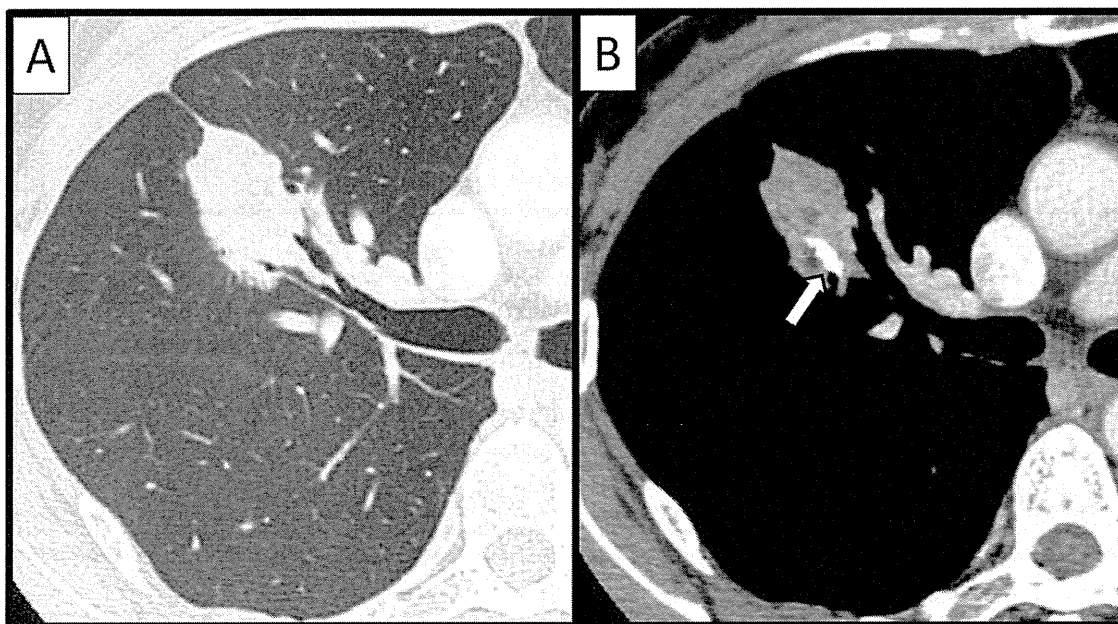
Chest CT of the second tumor 8 years and 3 months after surgery (A: lung window and B: mediastinal window). The tumor involves the stapler line of the first operation at the right upper lobe (arrow).
